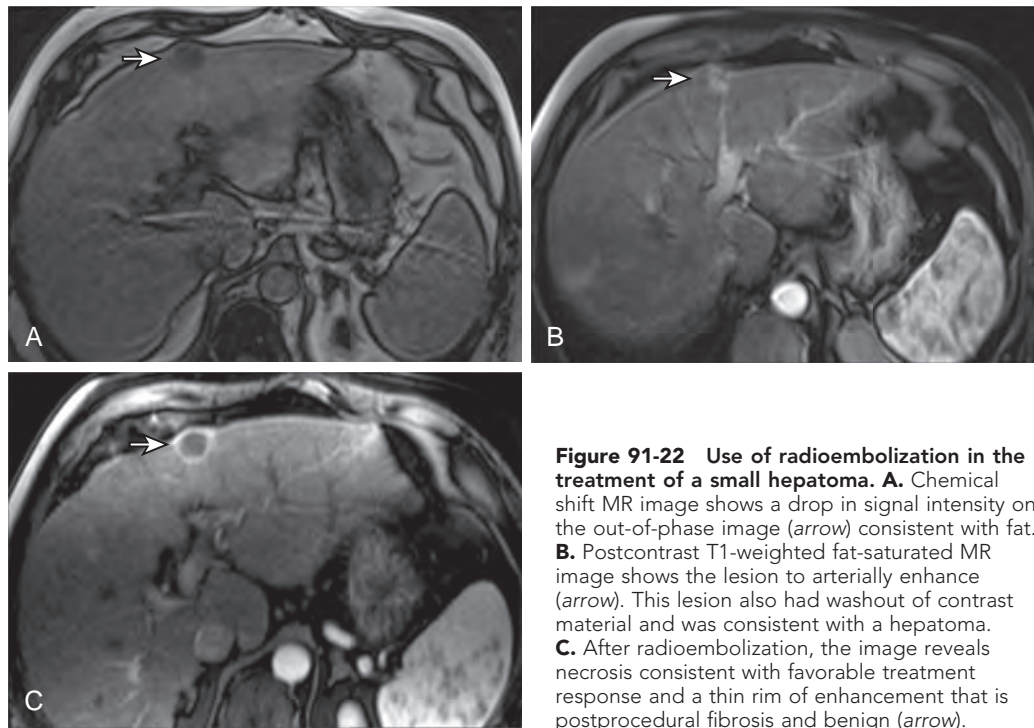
Use of radioembolization in the treatment of a small hepatoma. A. Chemical shift MR image shows a drop in signal intensity on the out-of-phase image (arrow) consistent with fat. B. Postcontrast T1-weighted fat-saturated MR image shows the lesion to arterially enhance (arrow). This lesion also had washout of contrast material and was consistent with a hepatoma. C. After radioembolization, the image reveals necrosis consistent with favorable treatment response and a thin rim of enhancement that is postprocedural fibrosis and benign (arrow).
